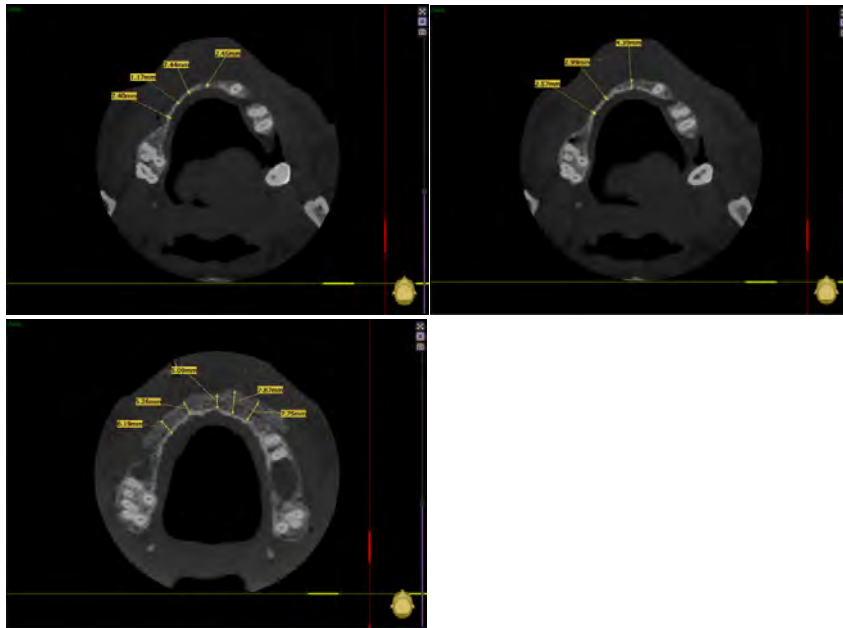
Postoperative CBCT view; axial section
